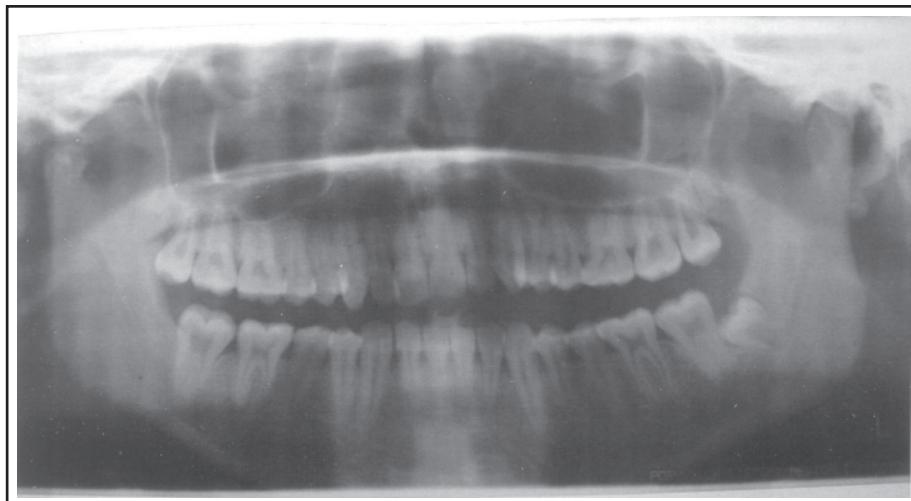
Postoperative orthopantomogram after one and a half year showing remodeled condylar stump of right side and no recurrence of growth.
